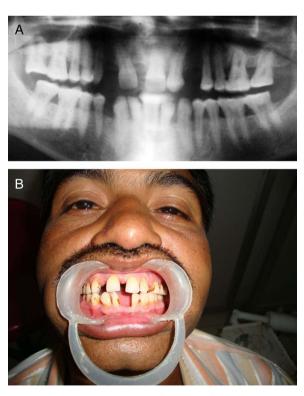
(A) Orthopantomograph of patient's father showing congenitally missing 12, 22, 31 and 41. (B) Photograph of the patient's father.
